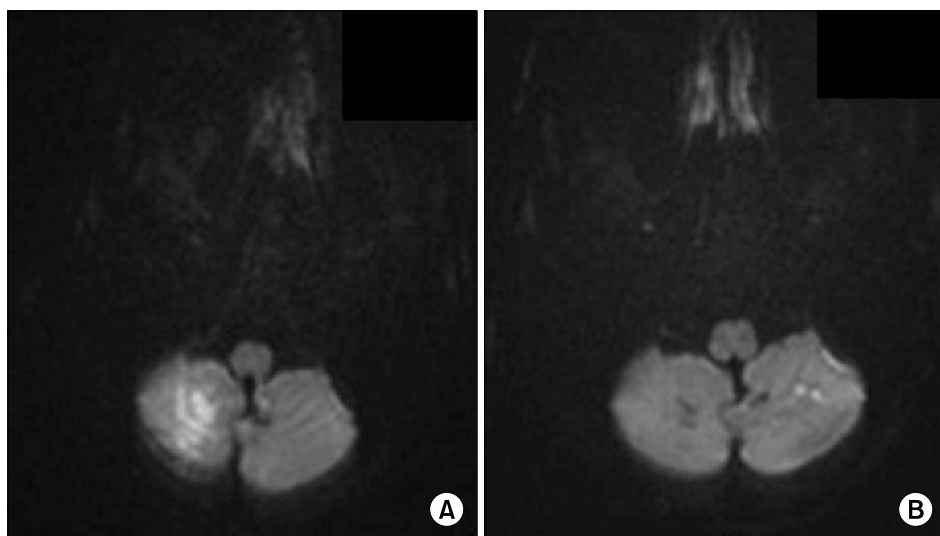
(A) The initial DWI image showed a 25 mm acute infarction in the right cerebellar hemisphere. (B) A follow-up DWI image taken 11 days later showed the regression of the acute right cerebellar infarction and a new acute small left cerebellar infarction. DWI, diffusion-weighted magnetic resonance imaging.
